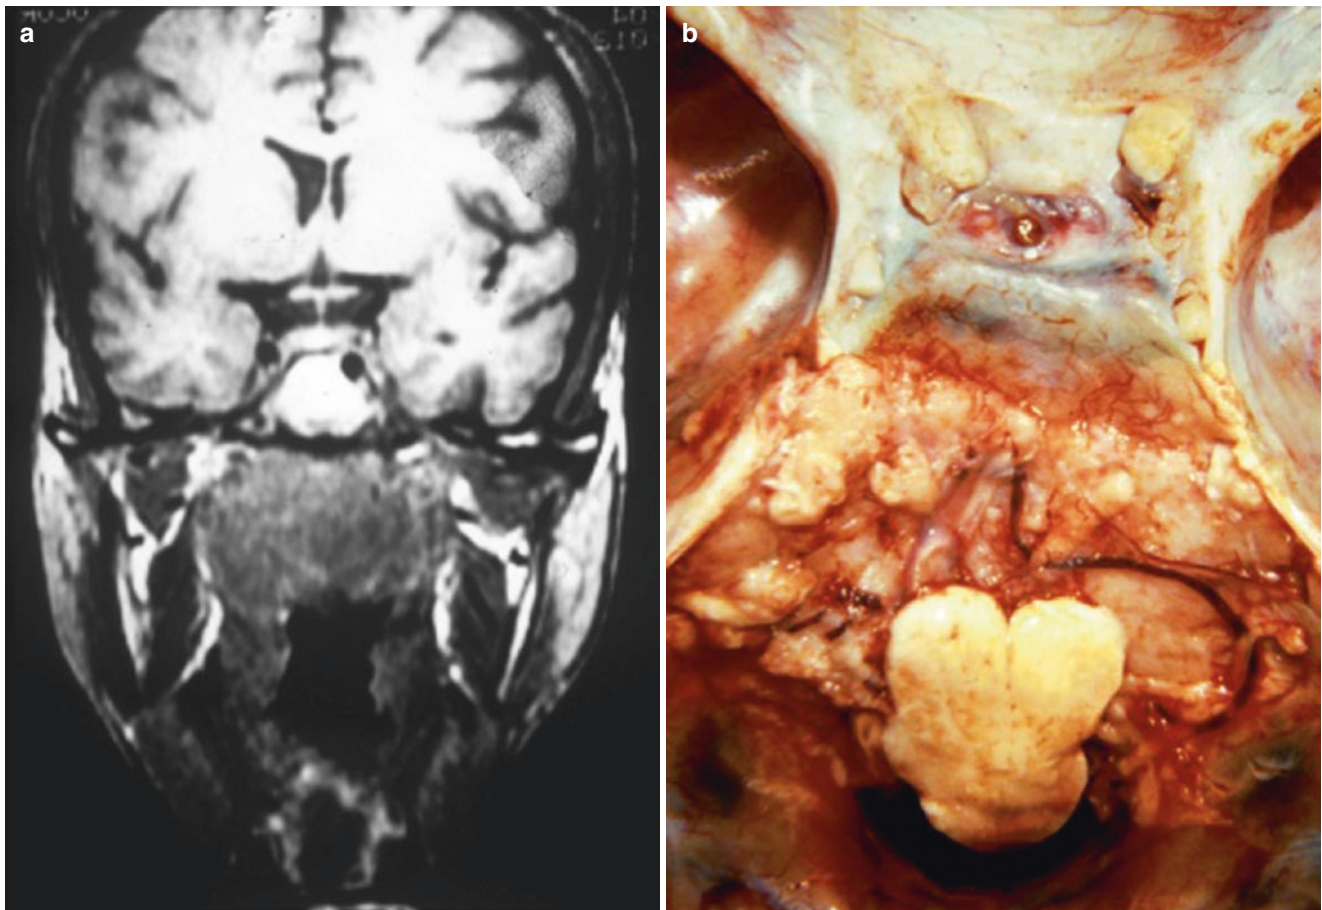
(a) Advanced-stage nasopharyngeal carcinoma. MRI showing invasion of the skull base and parapharyngeal space. (b) Grossly, the tumor infiltrates the skull base, the pons and the cranial nerves (Courtesy of Professor J. Traserra, Barcelona, Spain)
